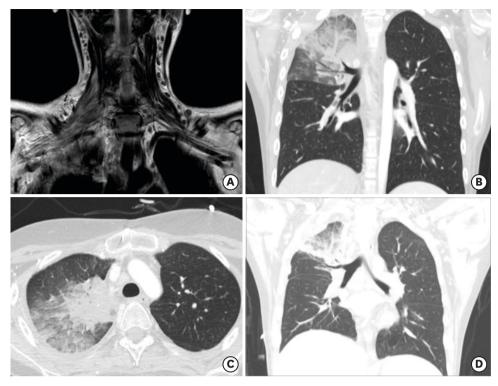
(A) Spine magnetic resonance imaging showing pulmonary consolidation in the right upper lobe, with edematous change and increased signal intensity at the right brachial plexus indicating brachial plexus impingement. (B, C) Chest CT images showing airspace consolidation, ground glass opacity, intralobular septal thickening in the right upper lobe of the lung and pleural effusion. (D) Chest CT image showing reduced consolidation and ground glass opacity in the right upper lobe after antifungal treatment. Abbreviation: CT, computed tomography.
